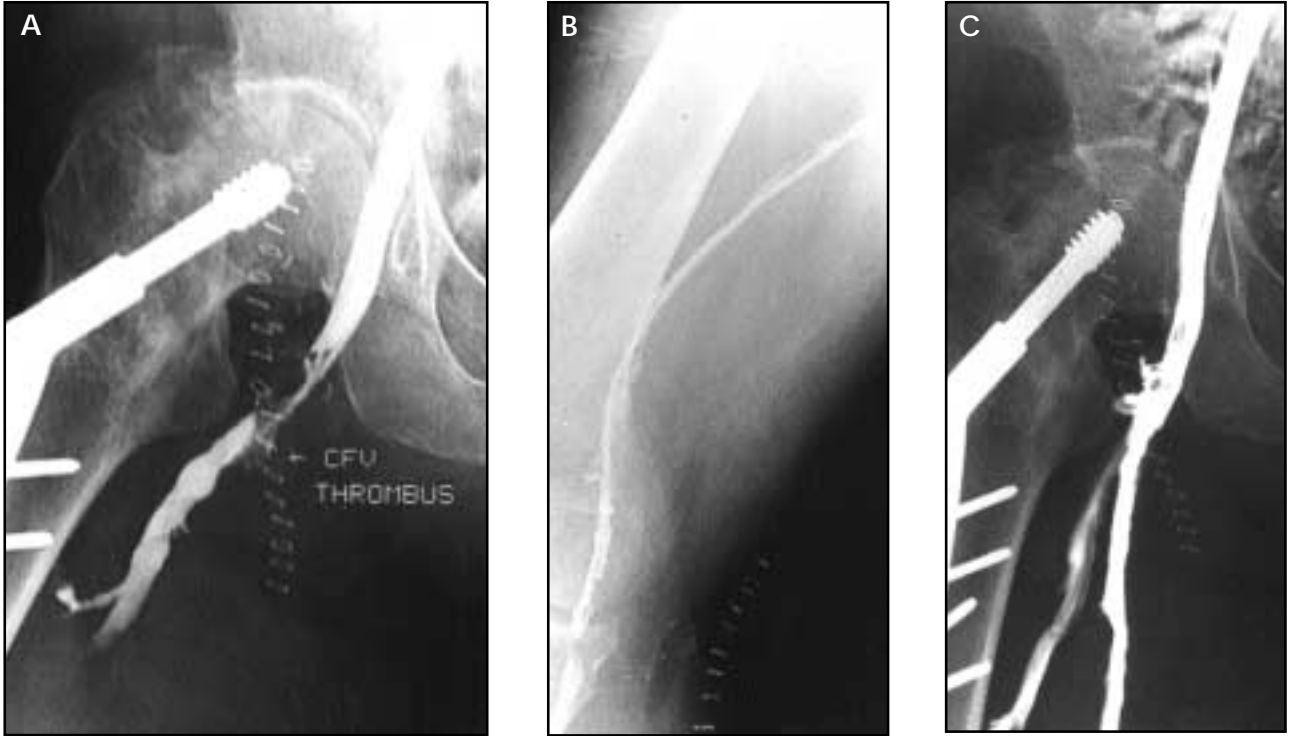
A 63-year-old man following right-leg arterial bypass. Right-leg swelling started 2 days after surgery, and ultrasound examination demonstrated extensive deep vein thrombosis (DVT). On the third postoperative day, the right lower leg was found to be cold and discolored, and arterial compromise was suspected. (A) Venogram performed from contralateral femoral vein access demonstrates nonocclusive thrombus within the left common femoral vein, and occlusive thrombus from the proximal superficial vein inferiorly. (B) Venogram performed following three passes with the AngioJet mechanical thrombectomy device shows thin lumen along path of thrombectomy. Patient was started on continuous alteplase infusion via a multi-sidehole coaxial infusion catheter. (C) Venogram after 18 hours of thrombolysis demonstrates common femoral and iliac veins without residual DVT. (D) After 18 hours of thrombolysis, nonocclusive DVT from superficial femoral vein to infrageniculate popliteal vein. Calf veins do not opacify. (E) After 2 days of thrombolysis, popliteal vein (and superficial femoral vein, not shown) is irregular in appearance but patent. There is persistent thrombus within the peroneal vein. Infusion was stopped at this point. The patient's right leg had improved significantly with restoration of normal color and resolution of swelling, except for the forefoot and midfoot, which were gangrenous and were amputated surgically.
